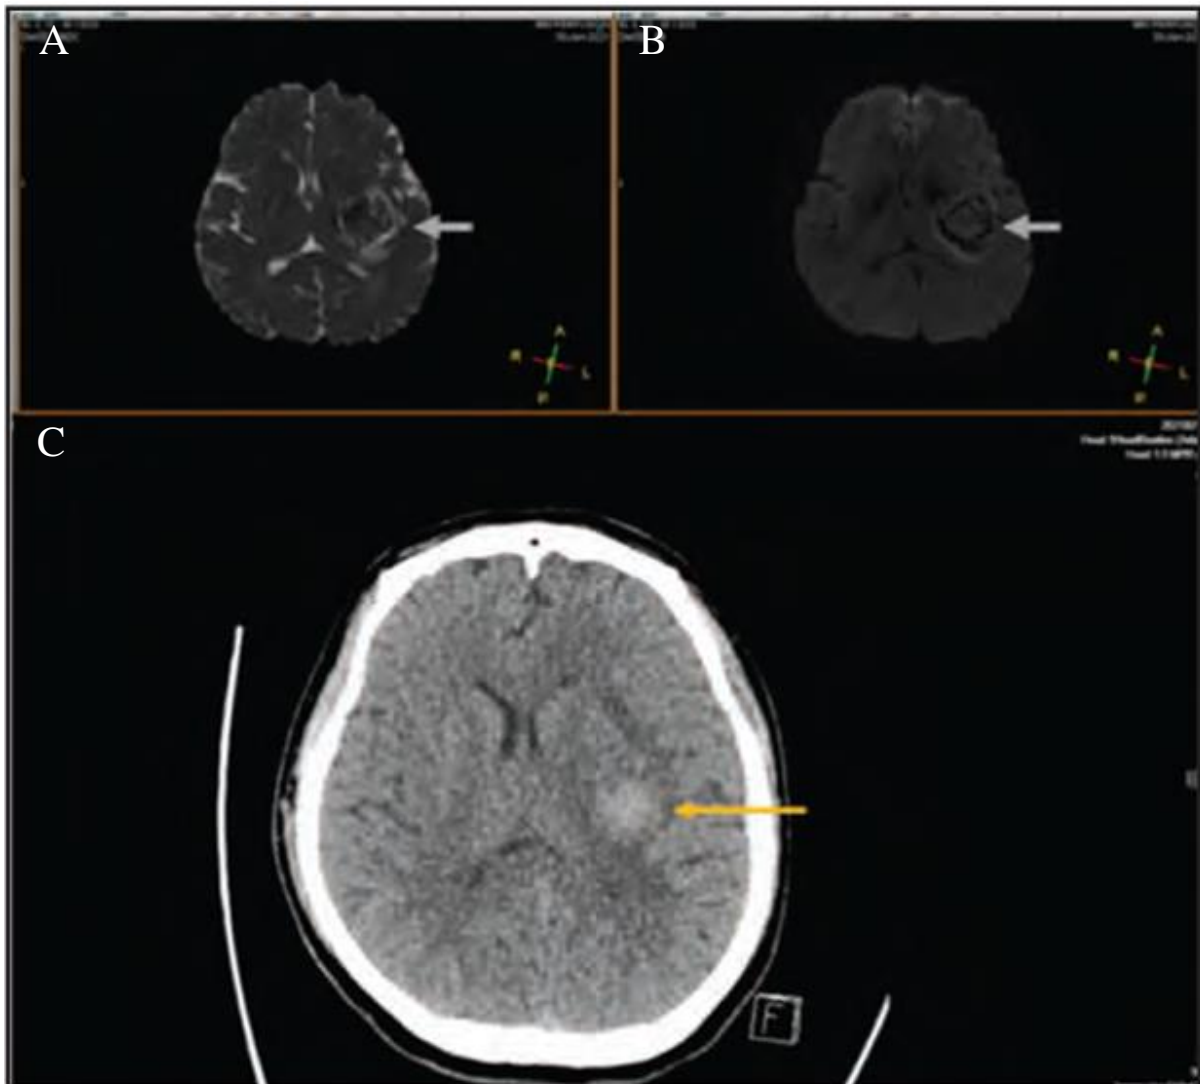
DWI shows central hyperintensity with surrounding hypointensity rim with the outer hyperintense rim in b1000 and ADC, representing oedema (arrows, A). Comparison to SWI (B) and CT (C) of the same patient. Adapted from Kamis et al. (2023).
